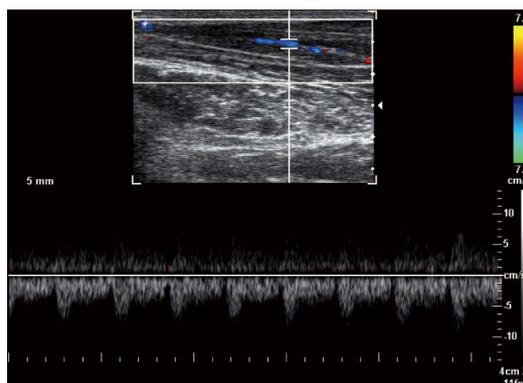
Spectral Doppler waveform of the median nerve shows low resistance hypervascularity of affected median nerve in a 40-year-old woman with severe carpal tunnel syndrome.
